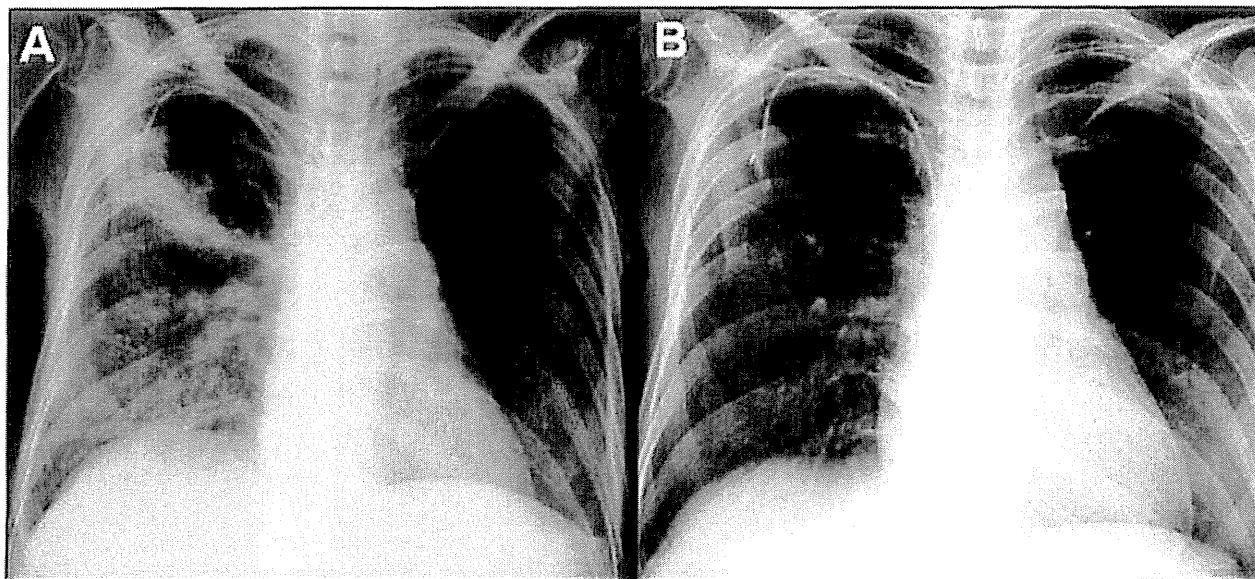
Chest x-ray before and on trastuzumab monotherapy. (A) Lymphangitic pulmonary metastases of right lower lung were suspected. (B) Abnormal finding improved with trastuzumab.
